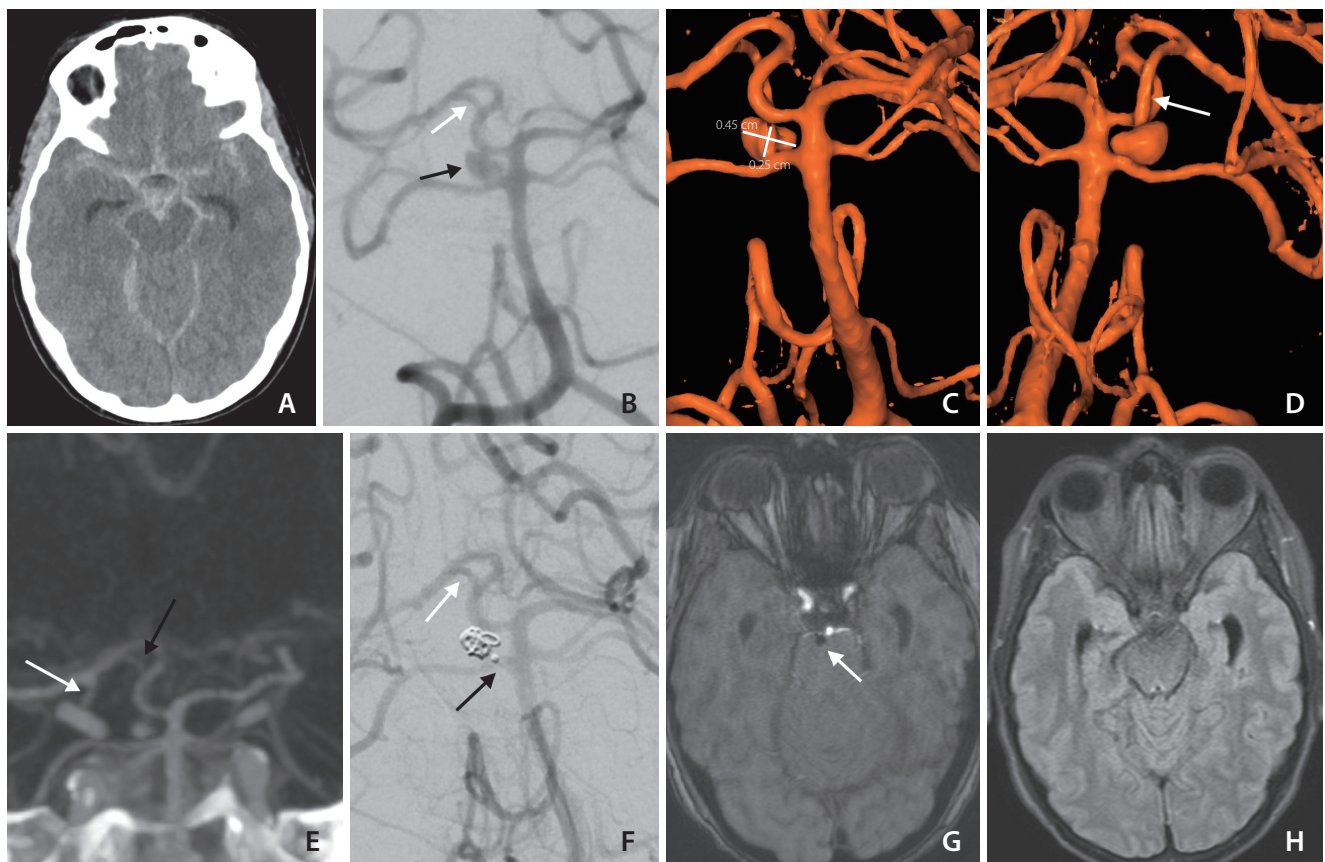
(A) Computed tomography (CT) of the head demonstrating diffuse subarachnoid hemorrhage. (B) Catheter-based angiography approximately 1 week after presentation with subarachnoid hemorrhage demonstrating an aneurysm (black arrow) arising from the superior cerebellar artery (SCA)-posterior cerebral artery (PCA) anastomotic branch (white arrow). (C) Anterior-posterior view of 3D rotational angiography demonstrates a 4.5 mm×2.5 mm aneurysm that shares a neck with the SCA-PCA branch origin and is posterior to the SCA-branch junction. (D) Posterior-anterior view of 3D rotational angiography provides an alternate view of the aneurysm and the SCA-PCA branch (white arrow). (E) CT angiogram of the head with thick cut maximum intensity projection coronal slice demonstrating the SCA-PCA anastomotic branch (black arrow) and posterior communicating artery (white arrow). The posterior communicating artery is clearly separate from the anastomotic branch and joins the PCA more distally than the branch. (F) Raymond–Roy 1 occlusion of the aneurysm with coils (white arrow); still visible is the anastomotic branch between the SCA and PCA (black arrow). (G) Magnetic resonance imaging (MRI) angiography axial slice demonstrating the position of the coils (white arrow). (H) MRI T2/fluid-attenuated inversion recovery axial slice without evidence of ischemia.
